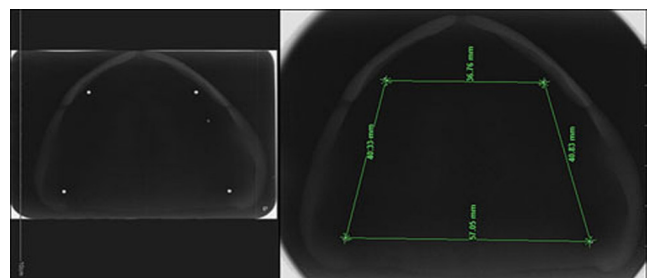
The radiographic image and reference lines on the master model
